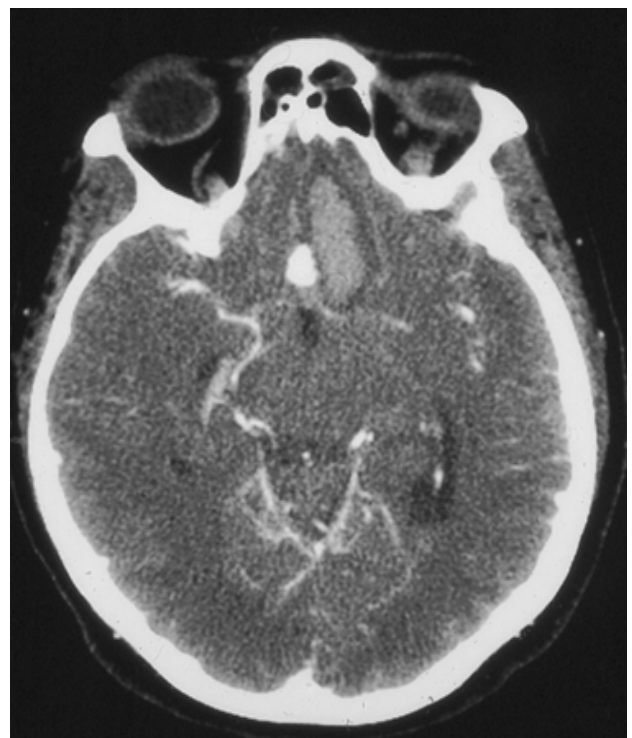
Cerebral CT angiography, axial projection, unedited (raw) image. Contrast media in arteries (thin black arrow), contrast media in the aneurysm (blue arrow). Bleeding into the brain near the aneurysm sac (thick black arrow).
